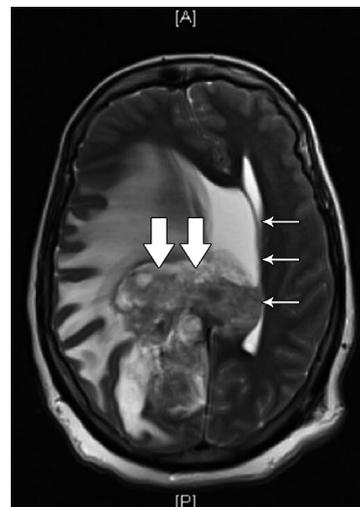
Brain MRI (10 days post-partum); showed more necrotic component in the tumor (wide arrows), midline shift to the left (narrow arrow), and tonsillar herniation (not shown).
